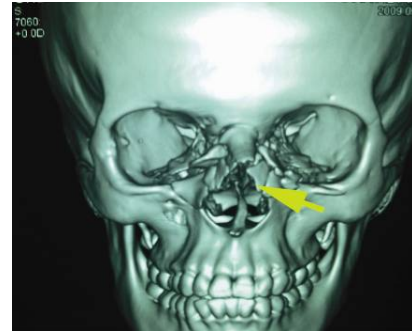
Photograph showing reconstructed 3D from CT of the same
